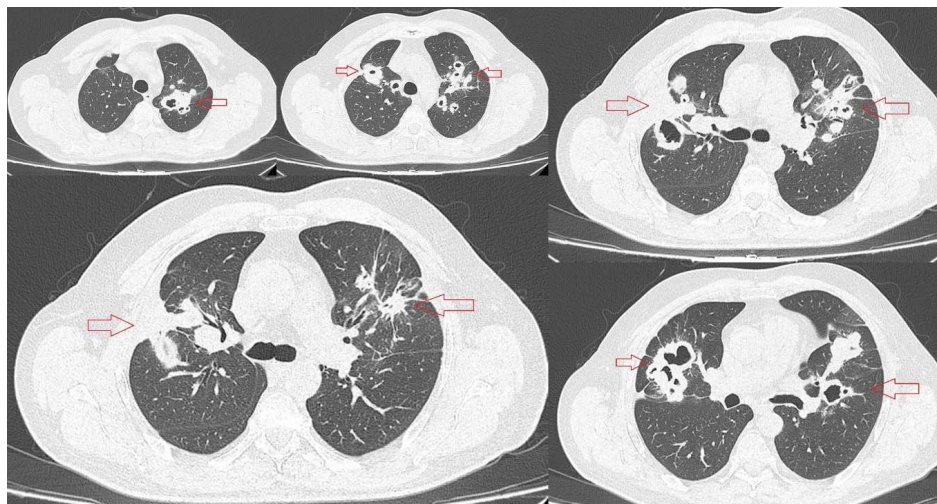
CT scan - Dimensional regression of nodular lesions in the right and left lower lobes, currently with cavitary images (red arrows)
